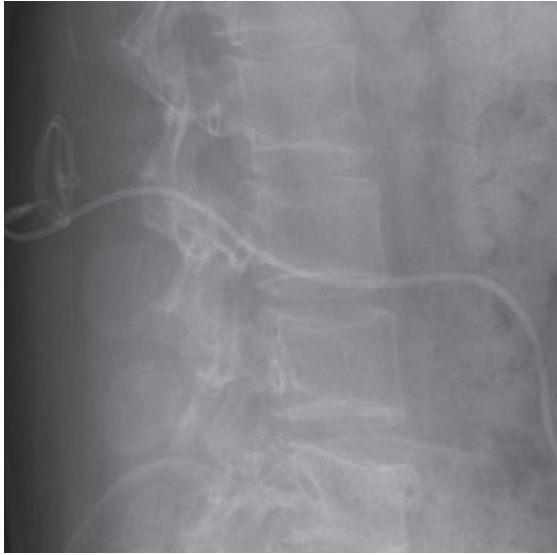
X-ray following a suprapubic cystotomy, showing no disconnection. The intrathecal catheter is retracted and curled at the level of L2.
